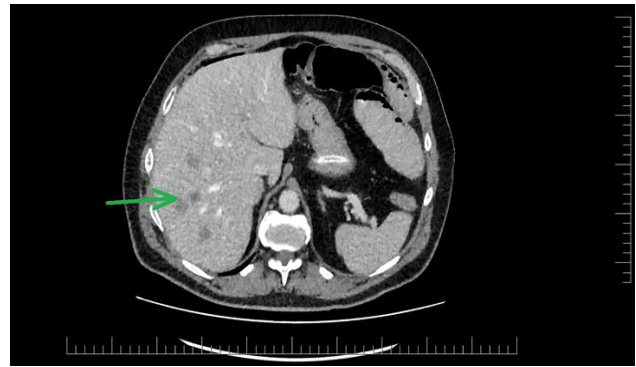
CT image from a whole-body staging examination in transverse plane showing multiple foci of liver metastases (reprinted with permission of patient)
